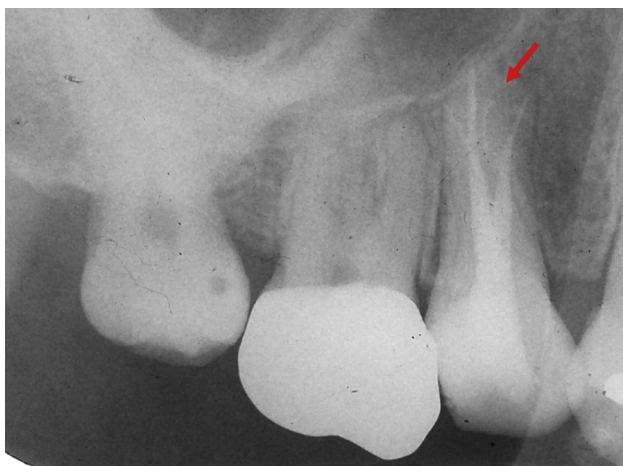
Postoperative periapical radiograph showing complete filling of the three main canals and lateral canal (arrow) by the warm gutta-percha vertical compaction technique.
